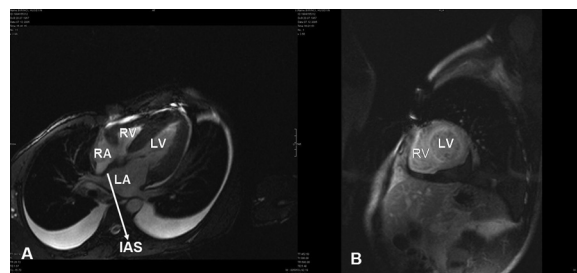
Precontrast cardiac magnetic resonance image shows increased left ventricular, right ventricular, and interatrial septal thickening (A). Short-axis delayed contrast-enhanced magnetic resonance image shows left and right ventricular diffuse enhancement (B). RV indicates right ventricle; LV, left ventricle; RA, right atrium; LA, left atrium; IAS, interatrial septum.
